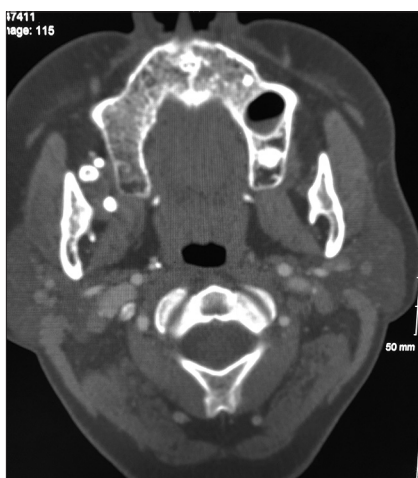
Computed tomography angiography axial image showing multiple round, well-corticated phleboliths situated between the maxilla and mandibular ramus
